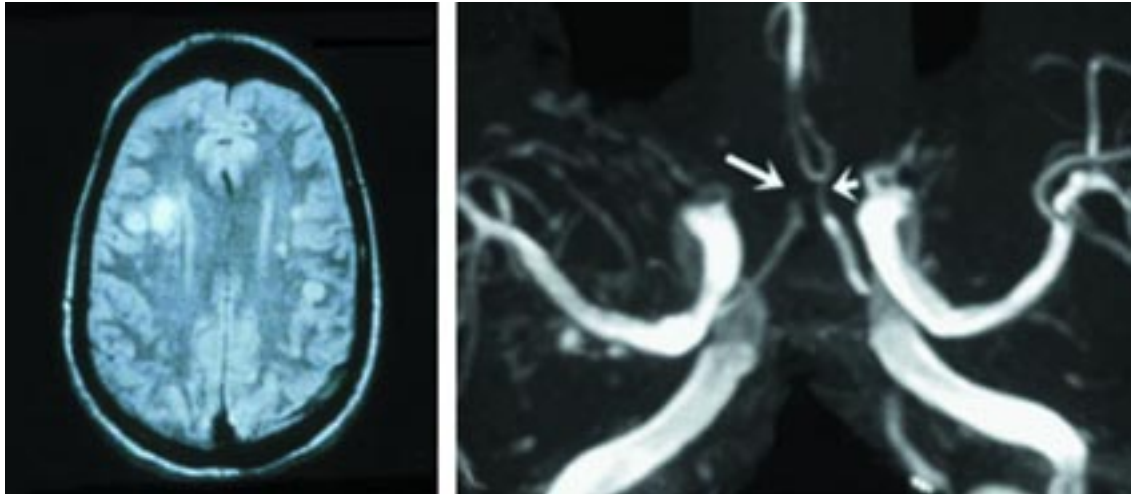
Left, magnetic resonance imaging of the brain shows multiple areas of infarction in both hemispheres, primarily involving white matter and gray-white matter junctions. Right, three-dimensional time-of-flight magnetic resonance angiography of the circle of Willis shows marked narrowing of the anterior cerebral arteries with occlusion on the right (long arrow) and marked stenosis on the left (short arrow).
